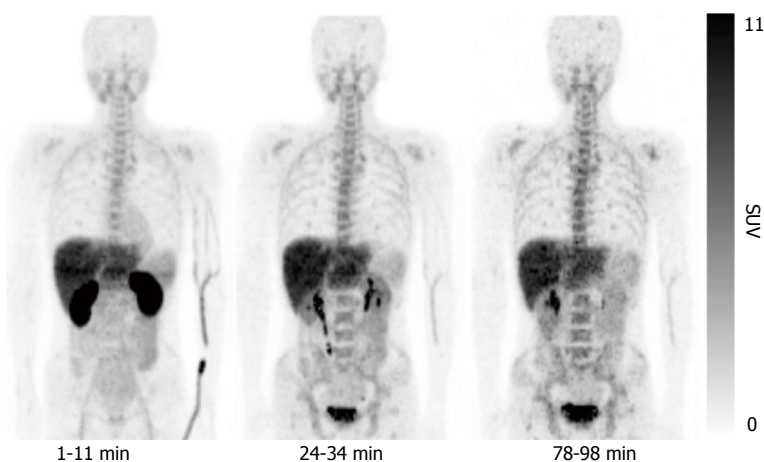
Representative whole-body decay-corrected maximum intensity-projection images of 4'-[methyl- ^{11}C]-thiothymidine positron emission tomography images. ^{11}C -4DST showed high uptake in the excretory organs, such as the kidneys, liver, and urinary bladder. Moderate uptake was observed in the proliferative organs, such as bone marrow, spleen, and small intestine. The lowest uptake was observed in the non-proliferating tissues, such as muscle and lungs. This research was originally published in JNM^[10]. ^{11}C -4DST: 4'-[methyl- ^{11}C]-thiothymidine; SUV: Standardized uptake value.
